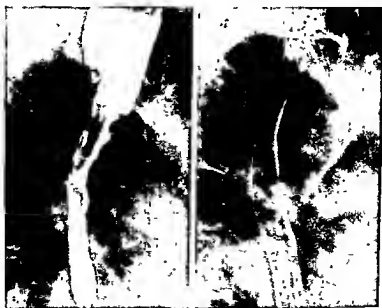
(Left) Esophagogram of male, 68 years old, with carcinoma of the thoracic esophagus which had produced obstruction and proximal dilatation. (Right) Roentgenogram of esophagus one year and eight months after beginning of treatment. Tumor dose 6,500 r/36 days.
